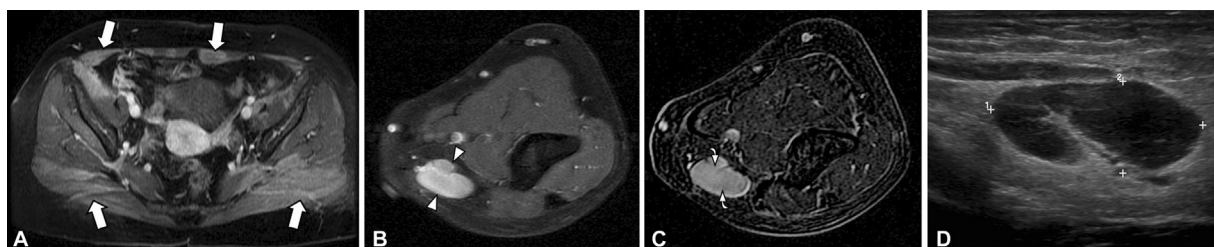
A 38-year-old female with sarcoidosis, lower extremity weakness, and elbow mass. (A) Axial T1 fat-suppressed postcontrast magnetic resonance (MR) image shows nonspecific patchy enhancement of bilateral gluteal and rectus muscles (arrows) which can be seen with sarcoid myopathy. (B) Axial T2 fat-suppressed MR image of the elbow in the same patient reveals a T2 hyperintense nodule (arrowheads) with solid enhancement on the (C) postcontrast axial subtraction image of the elbow (curved arrows) consistent with sarcoid granuloma. (D) Ultrasound image shows a heterogeneous hypoechoic mass with internal septation.
